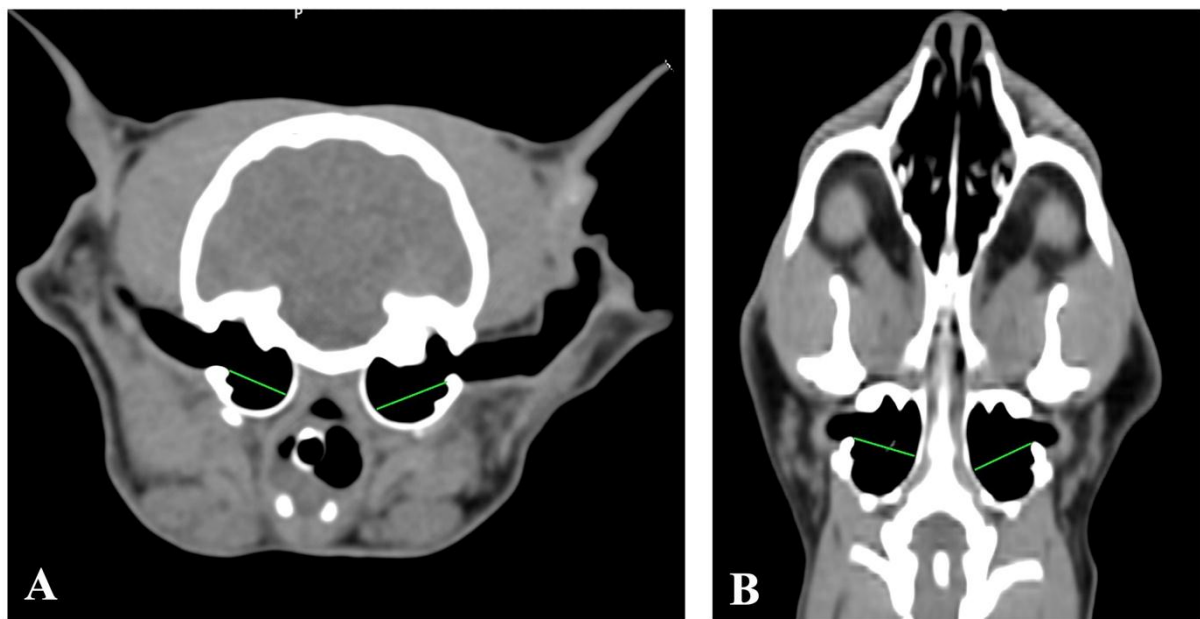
CT images depict tympanic bulla width measurement (green line) in the transverse plane (A) and dorsal plane (B).
